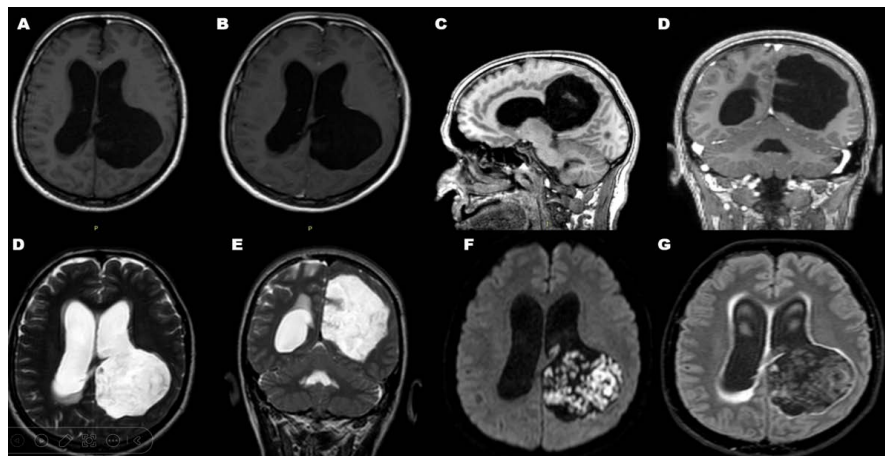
MRI revealing a large intra-axial cystic lesion in contiguity with the left lateral ventricle, compatible with an epidermoid cyst. T1-weighted axial view (A). T1-weighted post-contrast axial view (B). T1-weighted sagittal view (C). T1-weighted coronal view post-contrast (D). T2-weighted axial and coronal views (E and F). Diffusion-weighted axial view (G). Axial flair image (H).
